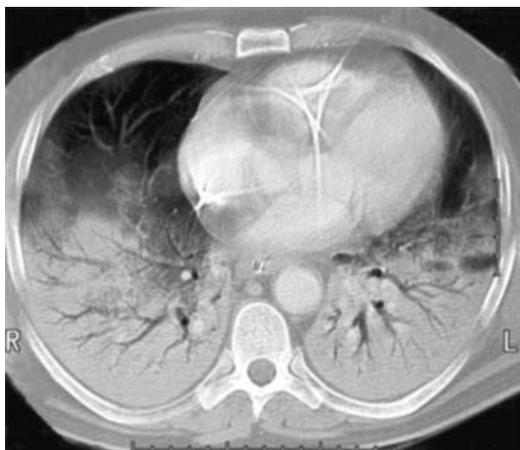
Computed tomography scan of the chest in a patient with acute respiratory distress syndrome. Note the densities in dependent parts of the lungs, indicating edema and consolidation. The larger airways are visualized by their aeration as compared to the surrounding collapsed and fluid-filled tissue ("air bronchogram"). Middle regions show "ground glass opacification."
